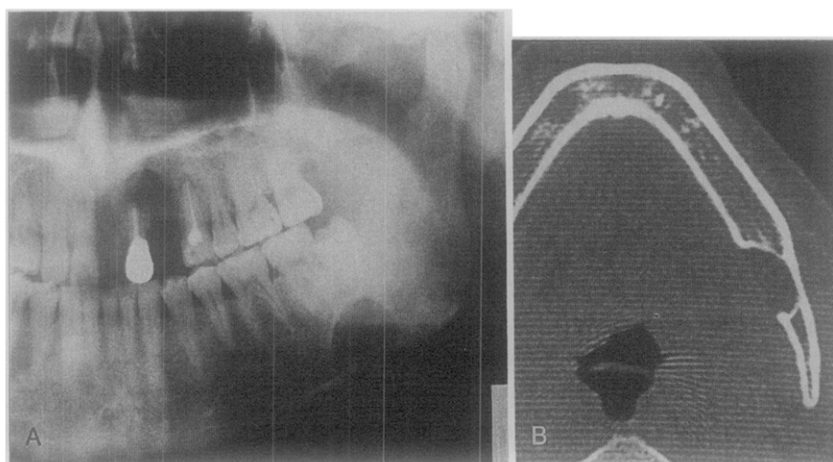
A, Panoramic radiograph of case 9 shows typical appearance of Stafne's bone cavity near angle of mandible on left side. B, Axial CT image shows that bottom of concavity reaches buccal cortical plate, which is not expanded.
